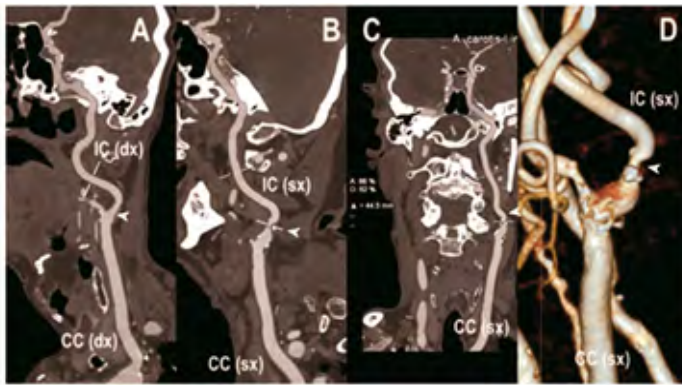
Carotid CT angiography using photon count computed tomography. The figure shows advanced reconstructions of a carotid artery vascularization.
